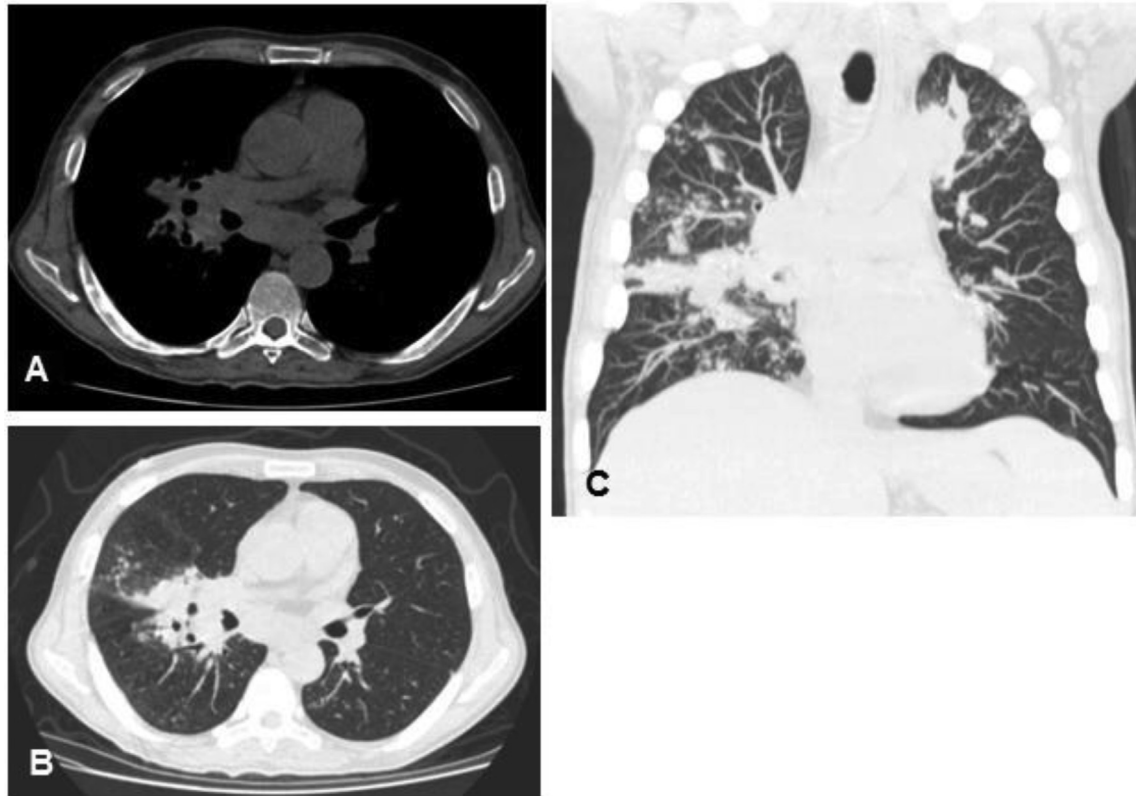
CT images from a 36-year-old man presenting with cough, fever, and weight loss. (A,B) The images reveal subcarinal lymphadenomegaly and cavitated lesions on the upper right lobe. (C) CT with coronal reconstruction demonstrated tree-in-bud centrolobular nodular disease in the right lung and left upper lobe. A biopsy of this node revealed tuberculosis.
